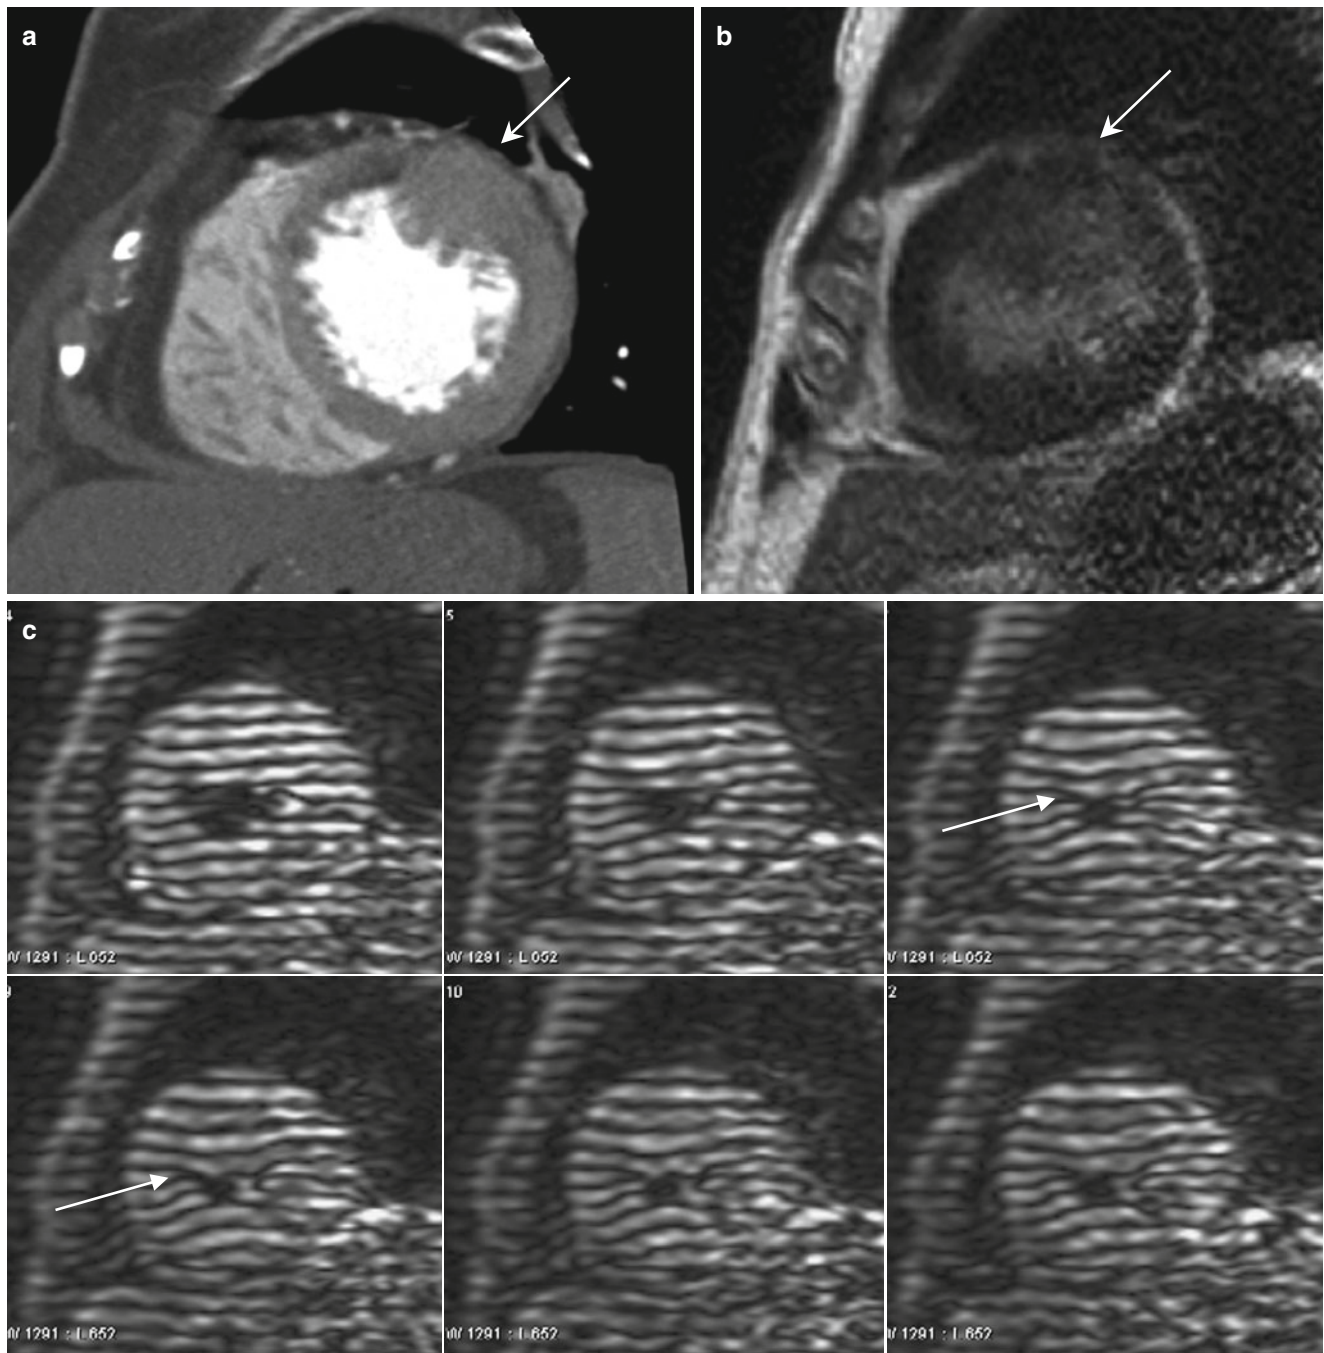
Mass-like HCM. (a) Short-axis MDCT image shows mass-like bulging contour at apical anterior wall (*arrow*). (b) Short-axis delayed-enhanced MR image shows focal patchy enhancement within
